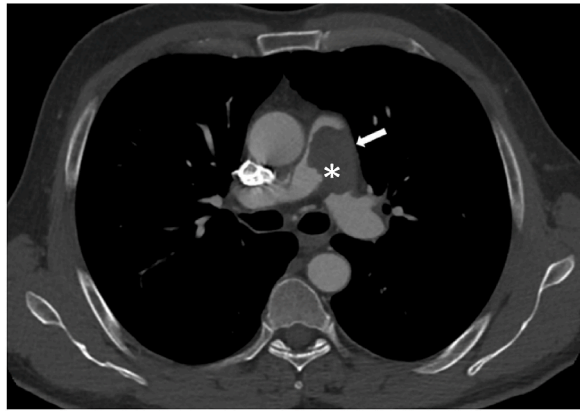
Axial CTA scans demonstrate the characteristic sign of PAIS. A hypodense area extends along the entire left wall of the common pulmonary trunk (white arrow), resembling the wall-eclipsing sign. The polylobulated margin (asterisk) depicted on the luminal side is another differential element with CPE.
